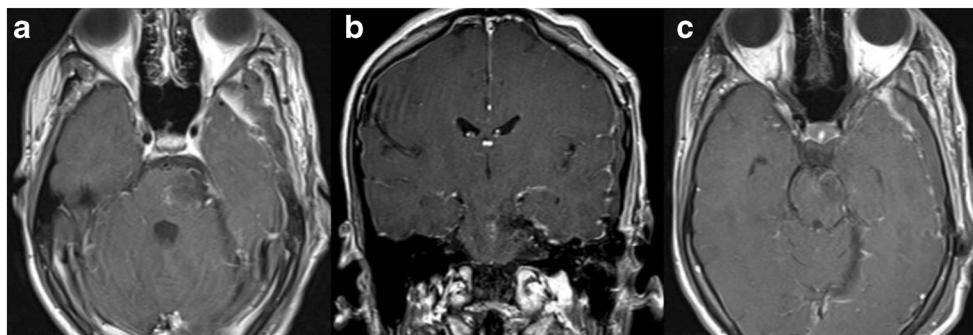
a–c Postoperative MRI showing the complete removal of the lesion
